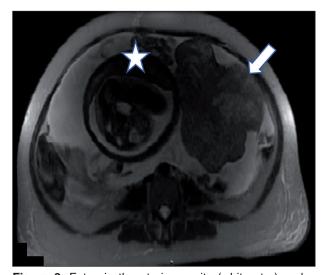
Fetus in the uterine cavity (white star) and a mass in the ovary (white arrow) observed on magnetic resonance imaging (MRI).
